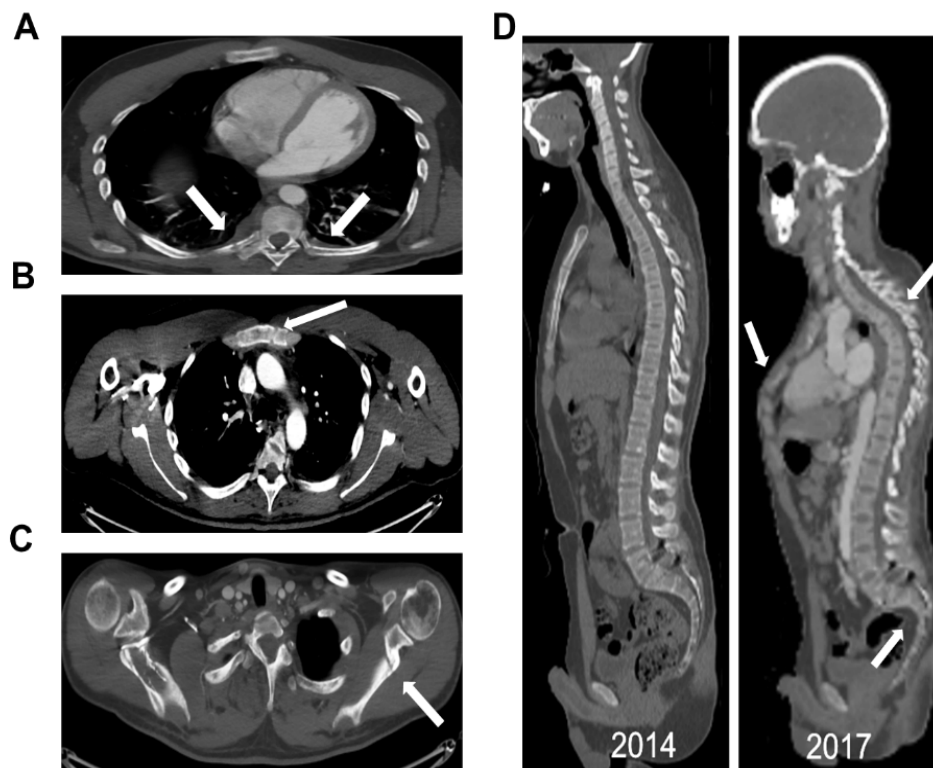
A. Axial CT demonstrating fractures (looser zones) of the posterior aspects of bilateral ribs. B. Axial CT demonstrating fracture (looser zone) of the manubrium sterni. C. Axial CT demonstrating fracture (looser zone) of the left scapula. D. Sagittal CT demonstrating dynamic changes and appearance of severe pectus carinatum with thoracic and sacral kyphosis.
